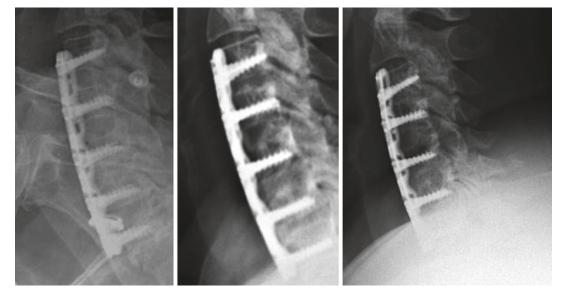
The potential for excessive subsidence leading to plate impingement on adjacent segments can occur with dynamic plates across multiple levels. This sequence of postoperative x-rays demonstrates this phenomenon over time
